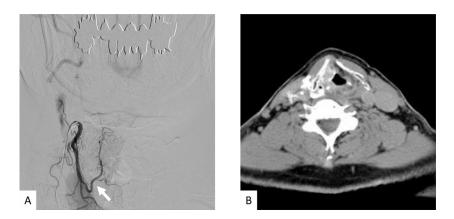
Angiography and IVR-CT images of a 71-year-old male with T3N0M0 stage III right glottic cancer (case 2). (A) Frontal angiography of the right superior thyroid artery (STA), including the superior laryngeal artery branch (arrow); (B) image of the right STA using a sliding computed tomography scanner system with interventional radiology features. The entire glottic tumor was enhanced.
